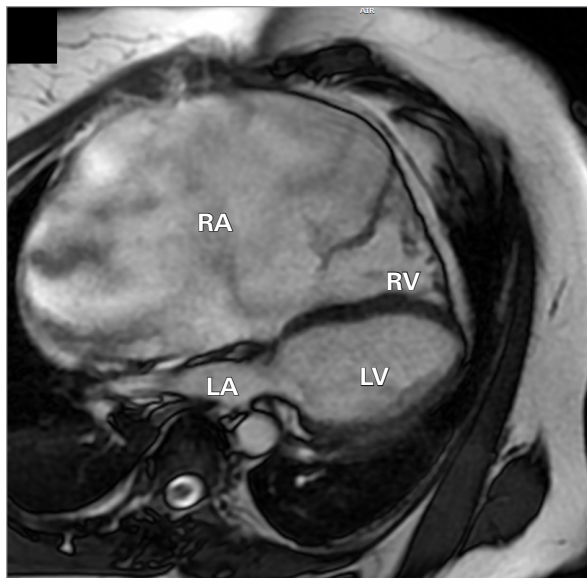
Cardiovascular magnetic resonance image in 4-chamber view showing cardiomegaly, with a normal-size right ventricle.
